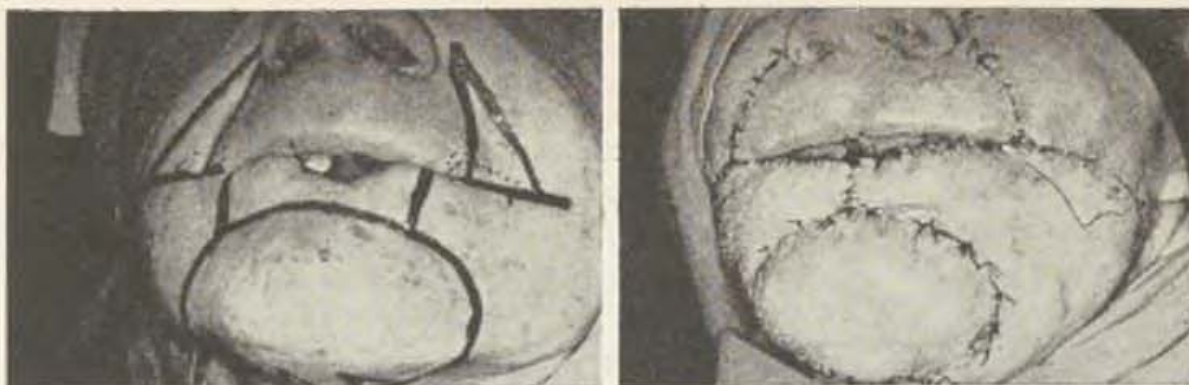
Recurrent spinocellular carcinoma of lower lip after X-ray treatment of 14,400 r total dosage. — Wound dehiscence after partial excision in section of lip suspect of malignancy. — Fig. 4b. Planning of operation for replacement of entire X-ray-damaged lower lip.
